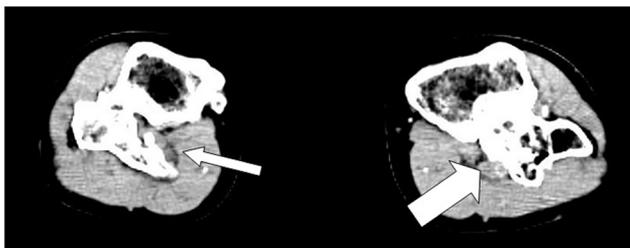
CT angiography views comparing the right (thin arrow) and left (thick arrow) popliteal arteries. The tumor is seen to completely envelop the left artery.
